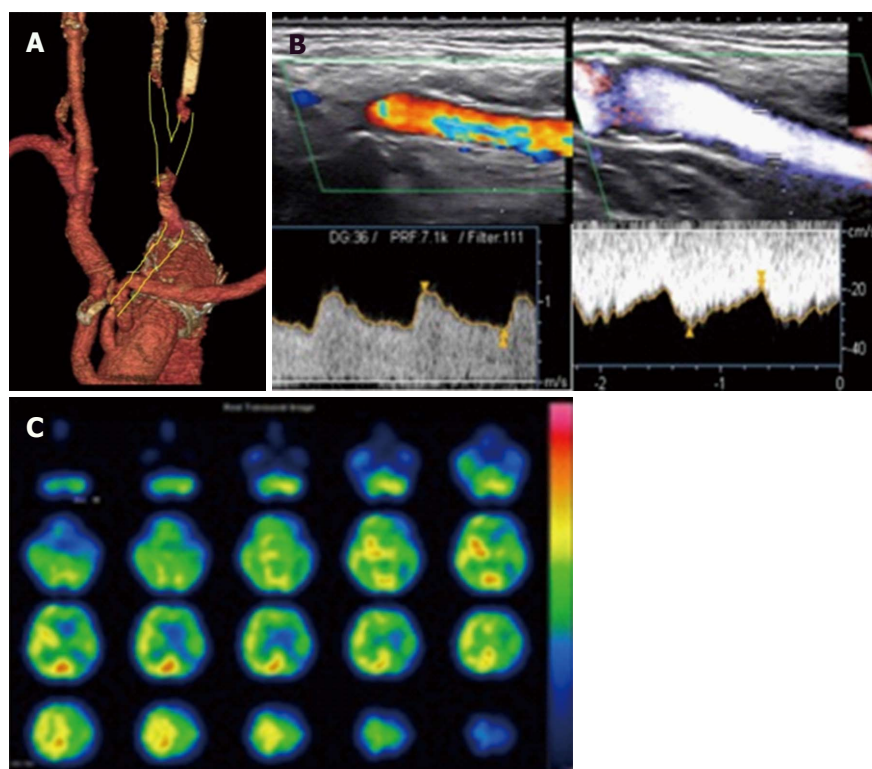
Enhanced computed tomography, color duplex sonography and single-photon emission computed tomography findings before bypass. A: Enhanced computed tomography findings. The yellow line indicates an occluded common carotid artery after total arch replacement; B: Color duplex sonography findings. There is retrograde flow from the external carotid artery (ECA) to the internal carotid artery (ICA). Before bypass, peak systolic velocity values for the ECA and ICA were 100 cm/s and 30 cm/s, respectively; C: Single-photon emission computed tomography findings. Before bypass, the cerebral blood flow was 29.66/20.92 mL/min per 100 g. The asymmetry ratio was 71%.
